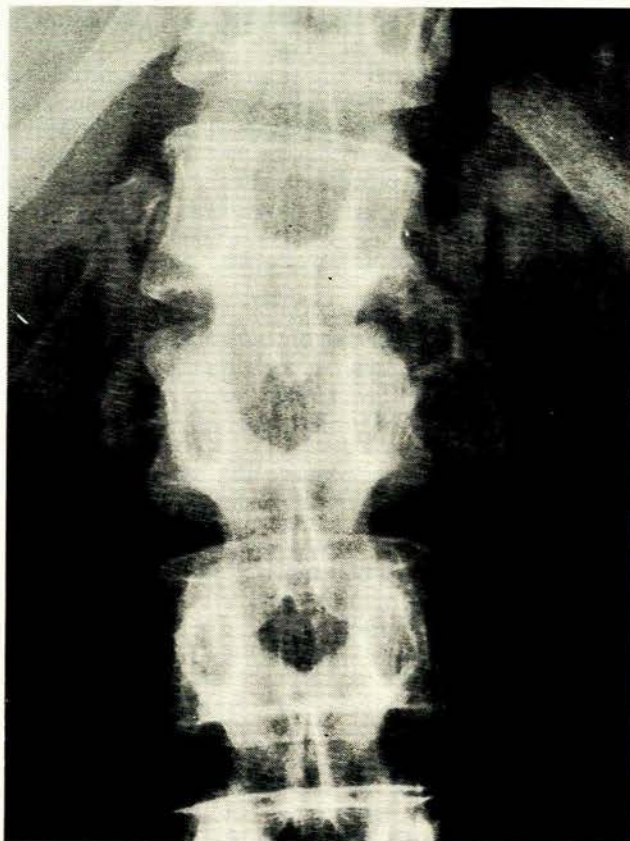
An anteroposterior X-ray of the lumbar spine. There is a narrowing of the disc space, destruction of the contiguous portions of the first and second lumbar vertebrae and calcification in the paravertebral soft tissues.
